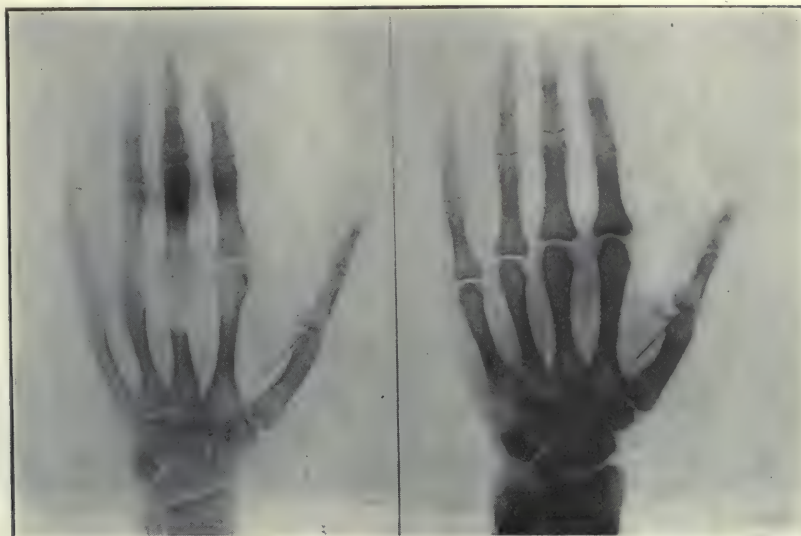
Stereoscopic radiographs of a needle in the hand. Reduced for the hand stereoscope.
